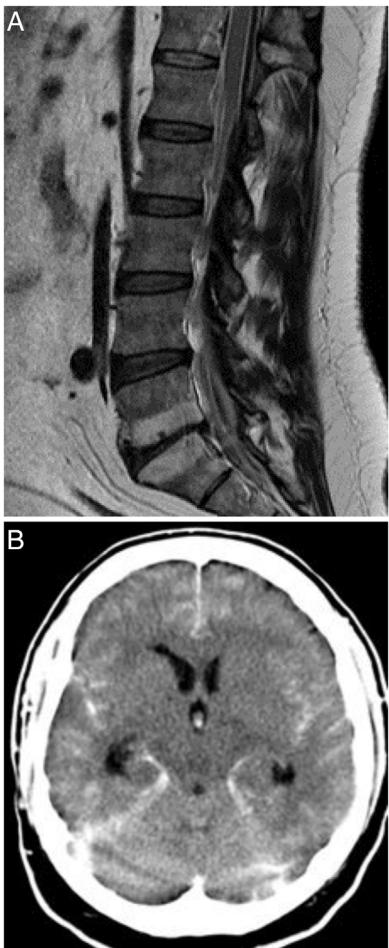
(A) T1-weighted MRI study of the spine (sagittal plane), showing epidural haemorrhage of the thoracolumbar spine. Loculi with greater posterior blood pooling are observed at the T12-L1 and S1–S2 levels. The morphology of the spinal cord is normal. (B) Non-contrast head CT scan showing perimesencephalic, intraventricular, and cerebellar subarachnoid haemorrhage (Fisher grade IV).
